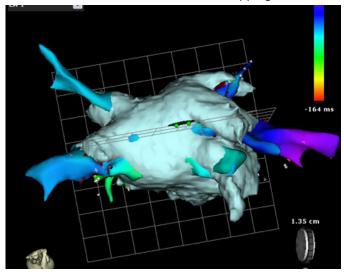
Image integration with the Carto system from Biosense Webster. Excellent fusion between computed tomography of the left atrium and electroanatomical mapping. Superior view.
